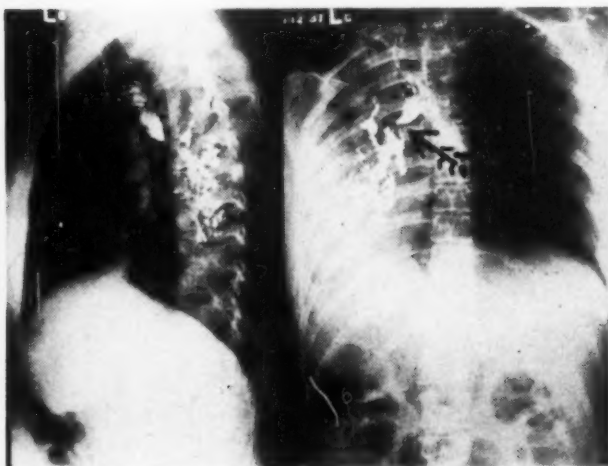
Roentgenogram of chest made after instillation of iodized oil in left bronchus of a woman, aged 27 years, revealed marked narrowing of left main bronchus (shown by arrow) with bronchiectasis of many subdivisions beyond the point of stenosis. The stenotic lumen is about 3 millimeters in diameter and resists dilation. There is practically no retention of secretion beyond the stricture except following acute respiratory infections. The sputum now is free from tubercle bacilli and she is symptom-free except for episodes of fever and chilliness with purulent sputum and evidences of retention of secretion with each respiratory infection. These respond promptly to bronchoscopy. The ultimate prognosis is unfavorable.
